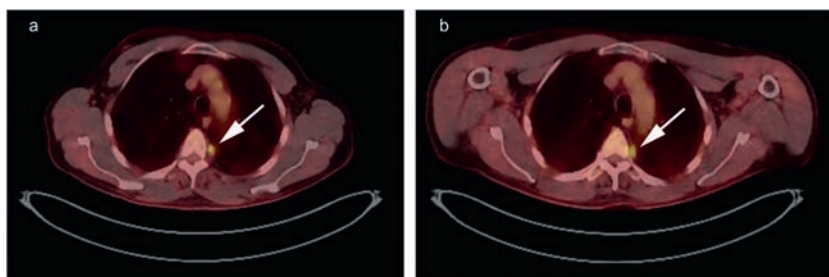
(a) FDG PET-CT scan demonstrating relapse of disease in the pleura of the left lung (white arrow) after 3 months of pause of therapy that followed a previous treatment period of cemiplimab for 1 year. (b) FDG PET-CT scan demonstrating further disease progression in the pleura of the left lung (white arrow) with increased size and FDG uptake following 3 months of pembrolizumab therapy, that is, PD-1 refractory disease.
